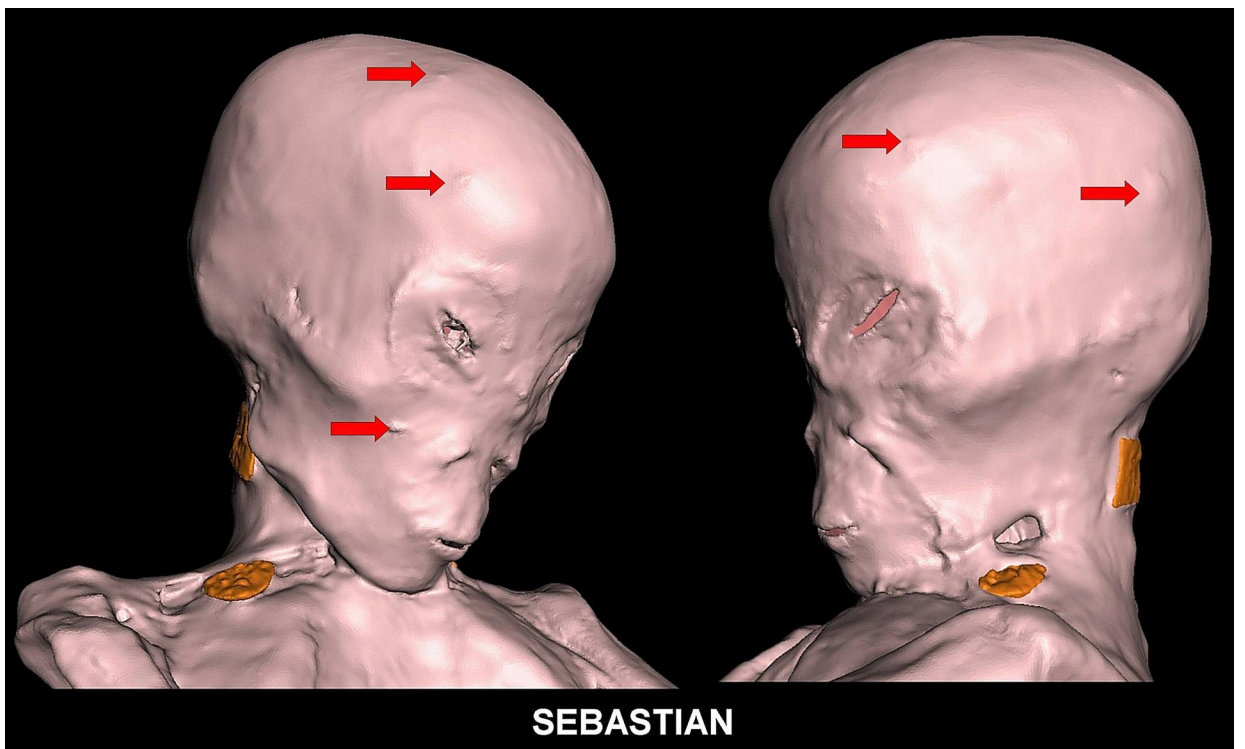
3D CT showing oblique views of head and neck. Note absence of ear canal and pinnae. Metallic implants were shown in orange colour. Tiny skin nodules were noted in scalp bilaterally and in right face (*red arrows*).
